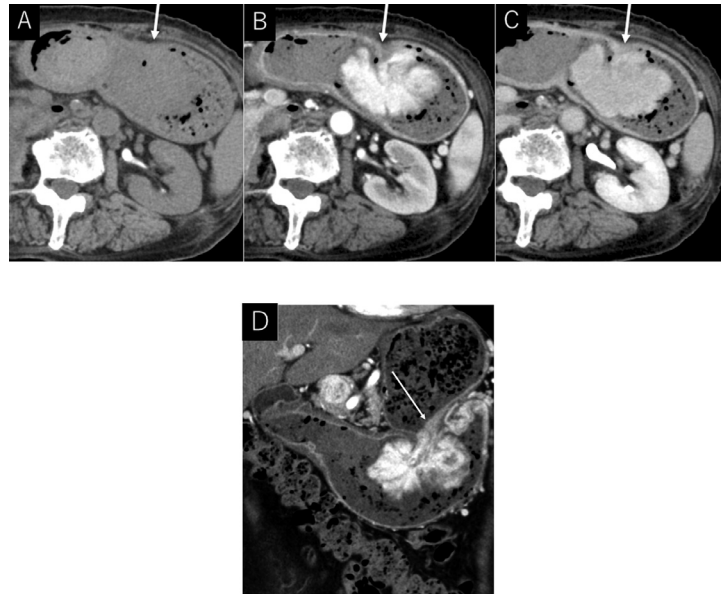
Dynamic contrast-enhanced computed tomography (CT) scans.
